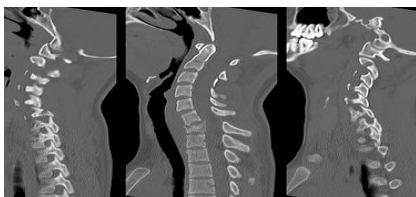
CT scan images showing a C7 fracture dislocation, with C7 body compression and facet joint fracture with subluxation
